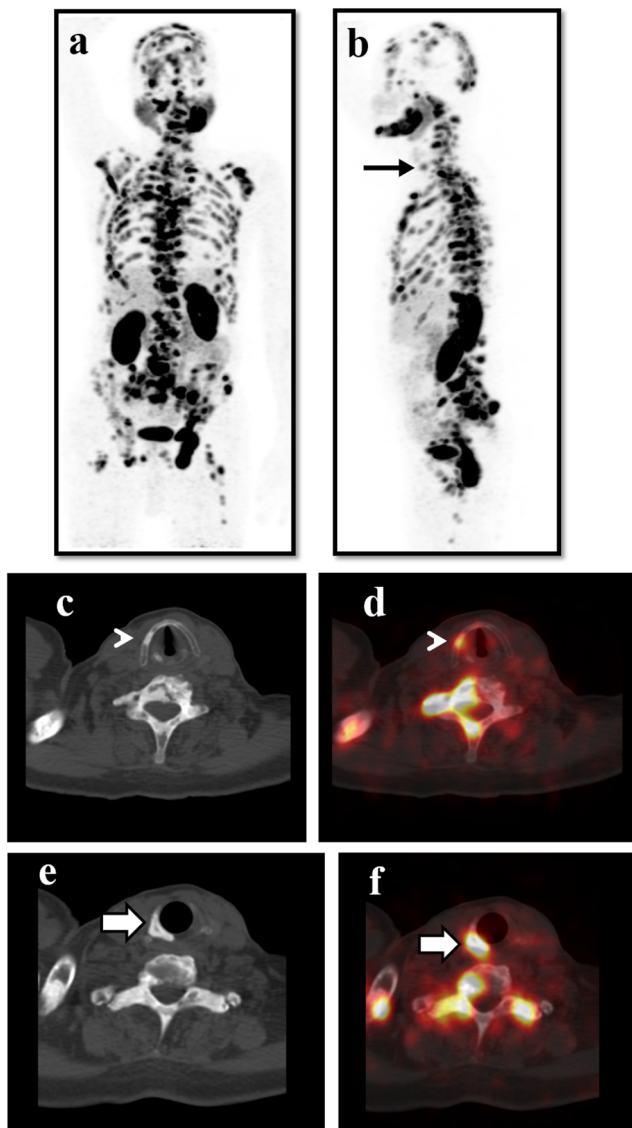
A 65-year-old male patient with newly diagnosed prostate adenocarcinoma (Gleason's score, 7 (4+3) and serum PSA, 208 ng/ml) was referred for ^{68}Ga -PSMA PET/CT for initial staging. Scanning was performed after injection of 3.0 mCi of ^{68}Ga -PSMA-HBED-CC (PSMA-11). Anterior maximum intensity projection (MIP) image of ^{68}Ga -PSMA PET image (a) shows extensive skeletal metastases in addition to the normal physiologic distribution where the uptake in the thyroid and cricoid cartilage is masked by uptake in vertebrae. Left lateral view of MIP image (b) shows increased radiotracer uptake in the region of larynx (black arrow). Axial computed tomography image (c) at the level of the thyroid cartilage shows sclerotic focus (arrow head) involving the right lamina of the thyroid cartilage. Corresponding fused axial PET/CT image (d) shows increased ^{68}Ga -PSMA uptake in the sclerotic focus. Axial CT (e) at the level of the cricoid cartilage shows sclerotic focus (solid arrow) involving the right lamina of the cricoid cartilage. Corresponding fused axial PET/CT image (f) shows increased ^{68}Ga -PSMA uptake in the sclerotic focus involving the cricoid cartilage. Also, the cervical and upper thoracic vertebrae and clavicle seen with tracer-avid sclerotic areas. Metastasis to laryngeal cartilages is relatively rare and mainly arises from renal cell carcinoma [1], melanoma [2, 3], and rarely from lung [4] and colonic carcinoma [5]. Metastasis to cartilages of the larynx from prostate adenocarcinoma is extremely rare and only few cases had been published until now [6–9]. Symptoms due to involvement of the larynx by tumor may involve hoarseness, dyspnea, stridor, and hemoptysis [7, 8]. Often, laryngeal metastasis presents with other distant organs including bones.
